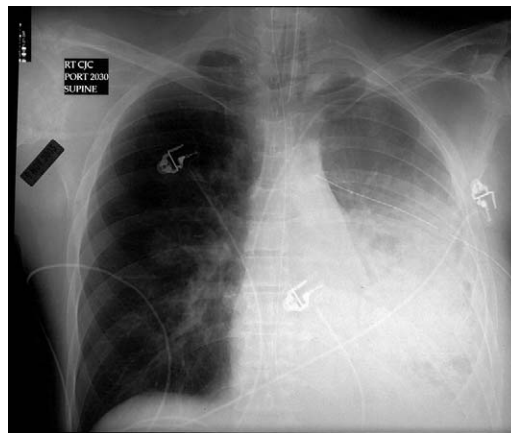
A postintubation chest radiograph demonstrates pulmonary edema limited to the left lung. The endotracheal tube, chest tube, and left subclavian central line are appropriately positioned. Used with permission of Timothy F. Platts-Mills, MD, the Department of Emergency Medicine, University of California, San Francisco-Fresno, University Medical Center, Fresno, CA.
